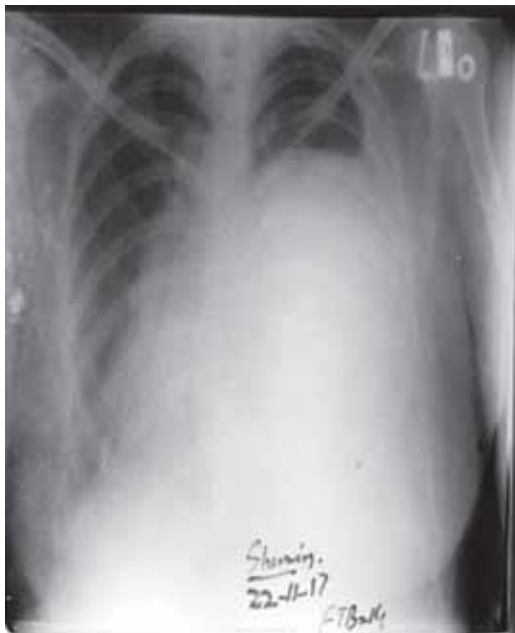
X-ray chest PA view showing homogenous opacity in left middle and lower radiological zone
